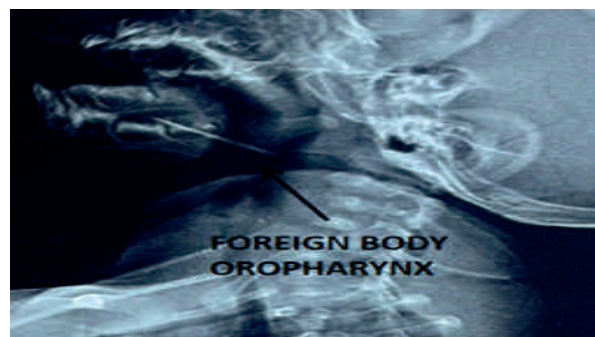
X-ray showing linear radio-opaque linear foreign body in the oropharyngeal area.
